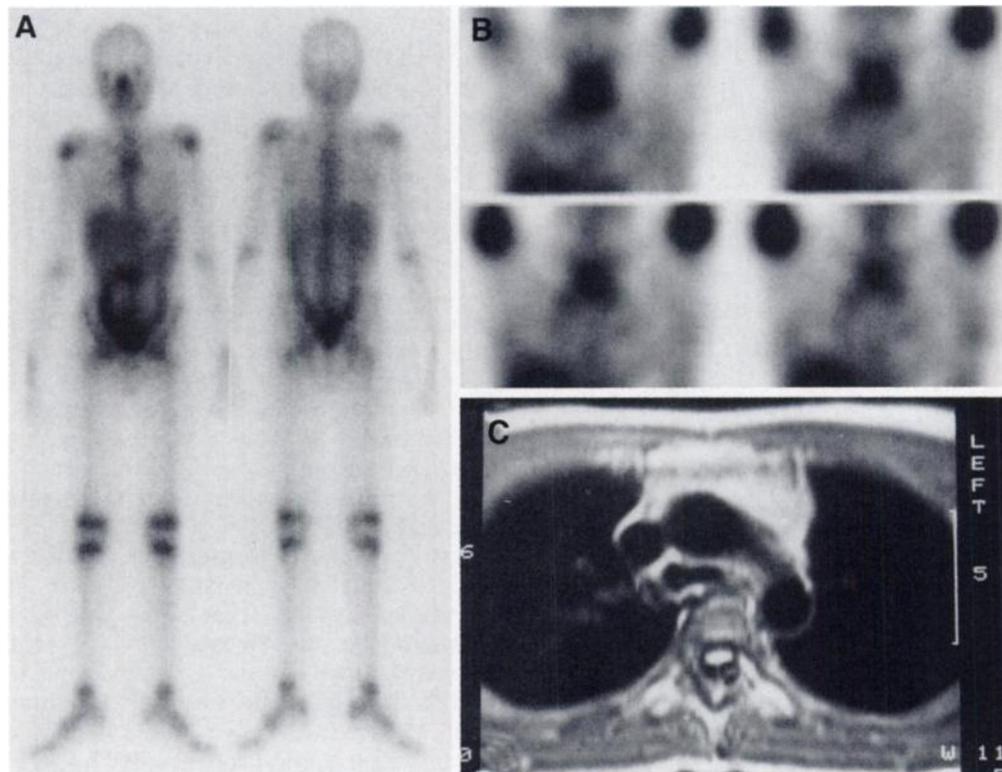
(A) Total-body image (anterior view) obtained 48 hr after injection of 185 MBq ⁶⁷Ga-citrate in 17-yr-old male patient with NHL. Note faint uptake in retrosternal region that is suspicious for persistent disease. (B) SPECT image of thorax shows important uptake of radiotracer, with extension near the paramediastinal region. (C) MRI also confirmed the presence of malignant tissue (proton-density image).
